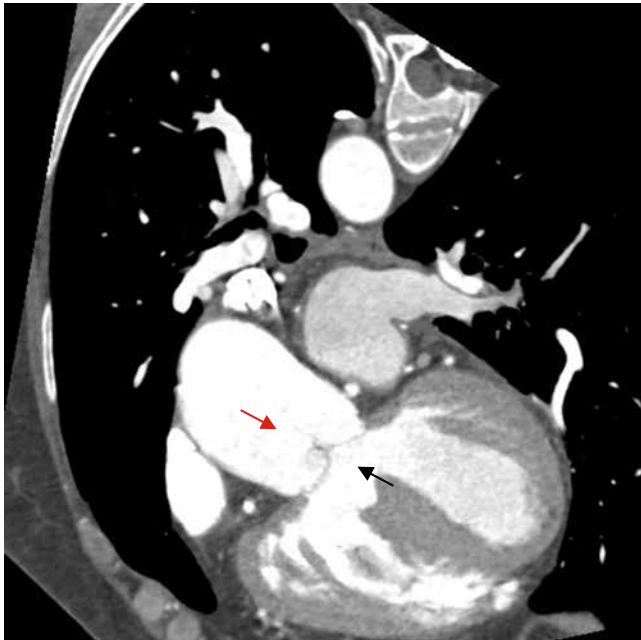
Computed tomography angiography of the heart and thoracic aorta. Ventricular septal defect (black arrow), overriding aorta with biventricular connection (red arrow)
